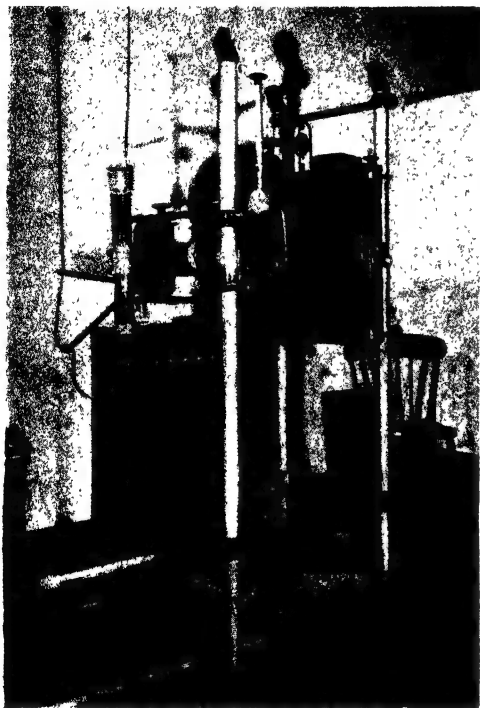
Upright radiographic stand.
